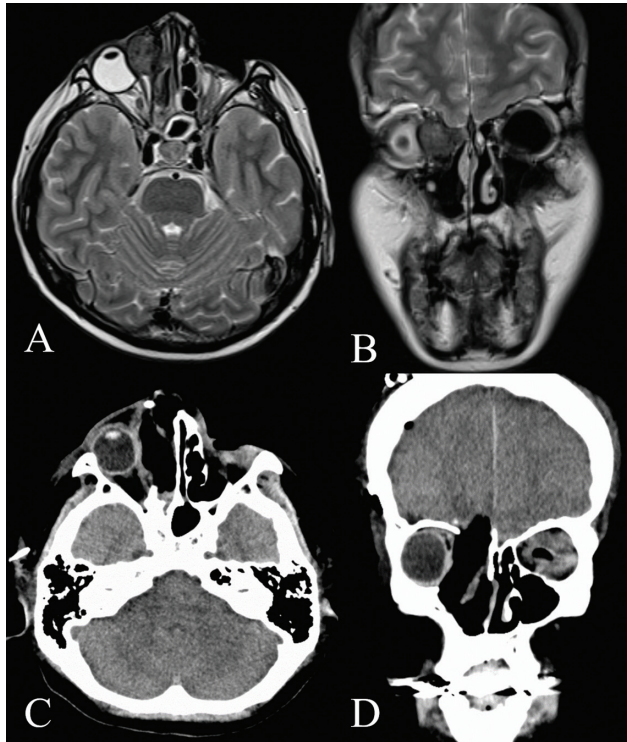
Preoperative axial (A) and coronal (B) T2-weighted magnetic resonance images demonstrating a 2 cm × 2 cm × 2 cm well-circumscribed tumor invading the ipsilateral cribriform plate, dura mater, and orbital periosteum; the nasal septum was intact. Postoperative axial (C) and coronal (D) computed tomographic images demonstrating that the tumor was completely resected and the left olfactory apparatus (epithelium, cribriform plate, and olfactory bulb) were spared.
